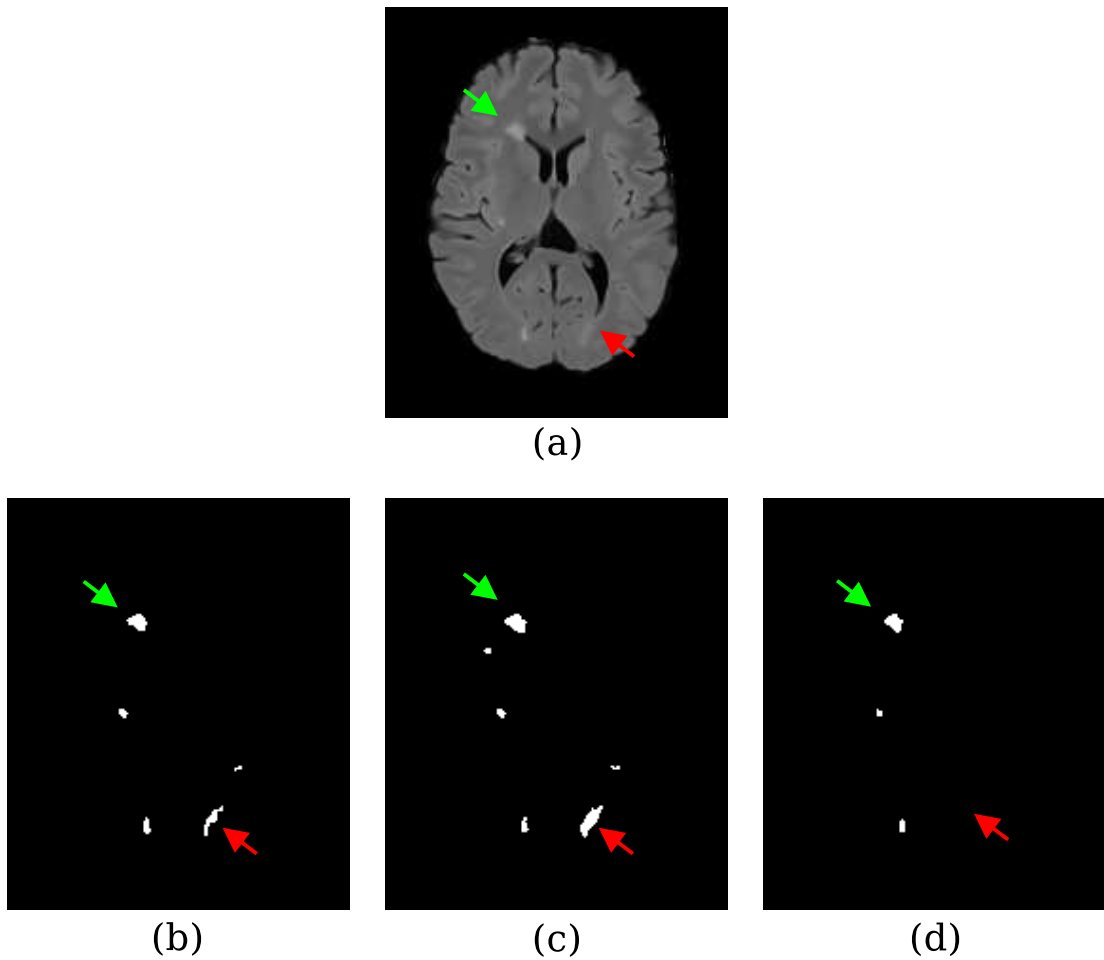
In (a), axial view of FLAIR. In (b)-(d), manual annotation from expert 1, 2 and automatic lesion segmentation, respectively. Green arrows indicate a hyperintense lesion identified in all three masks. Red arrows in the sub-figures indicate a less hyperintense lesion that was not identified by our proposed algorithm.
